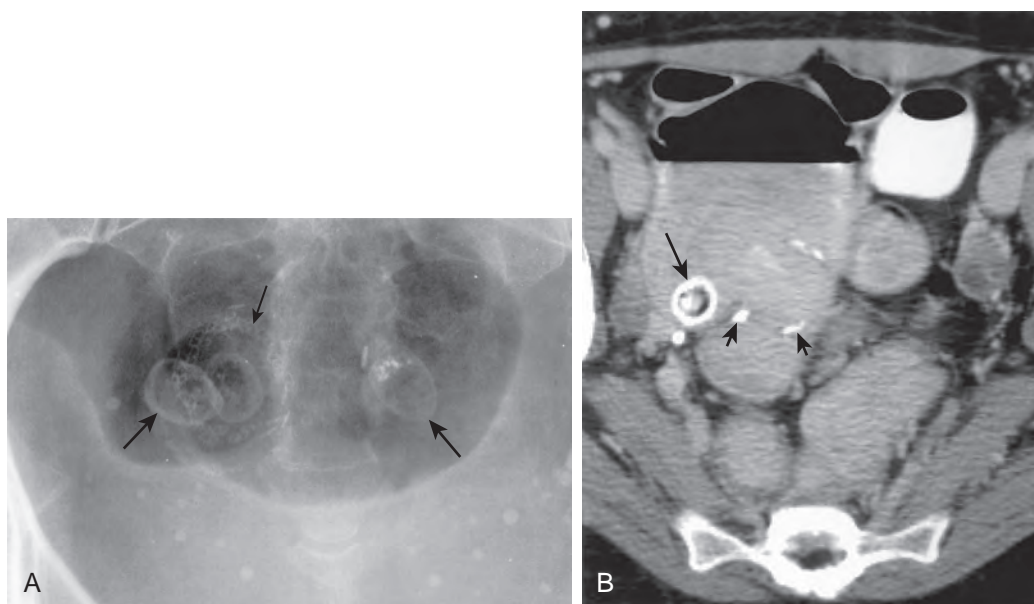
Enteroliths proximal to a stricture at the ileorectal anastomosis. A. Coned-down view from a plain abdominal radiograph shows three peripherally calcified ovoid structures (*large arrows*) near an anastomotic staple line (*small arrow*). B. Axial CT scan through the pelvis shows one of the enteroliths as a peripherally calcified structure (*large arrow*) containing central bubbles of air and soft tissue attenuation. Part of the staple line (*small arrows*) is identified.
